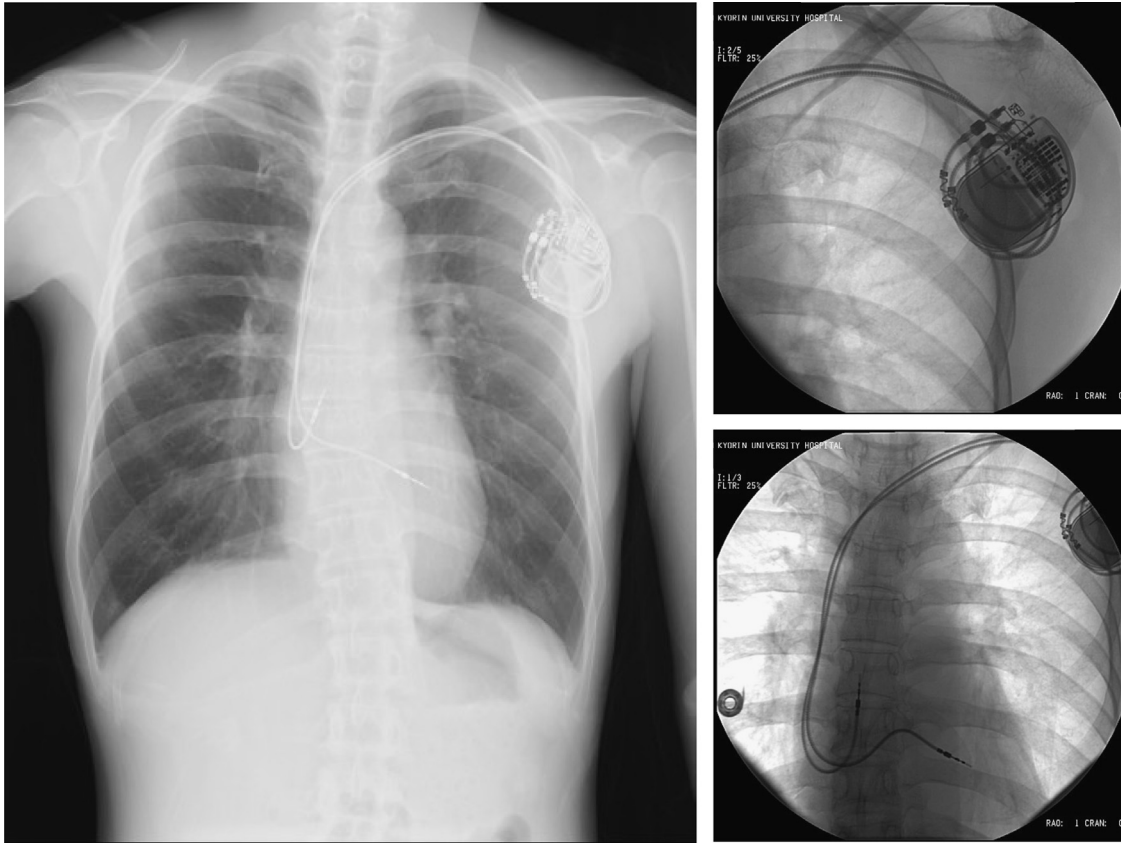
Chest radiography following MRI conditional pacemaker implantation. No abnormal findings are seen in the lungs.
